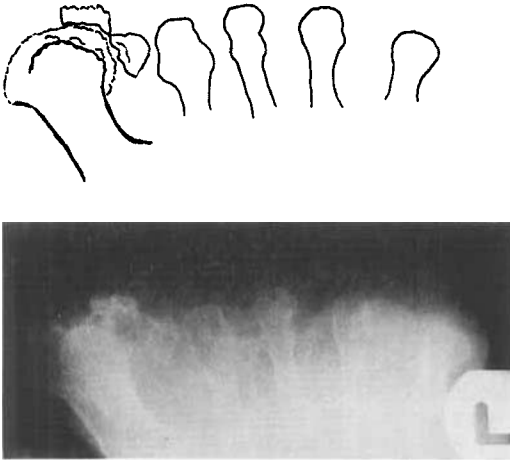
Tangential X-ray of the metatarsal heads in a patient with rheumatoid hallux valgus. The first web space is abnormally wide and the eroded sesamoid bones are dislocated between the first and second metatarsal heads.
